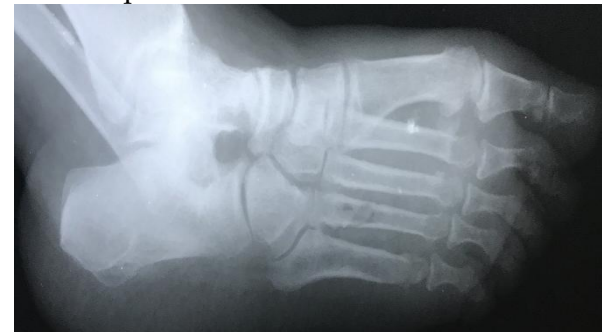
Six month's post-operative X-ray
